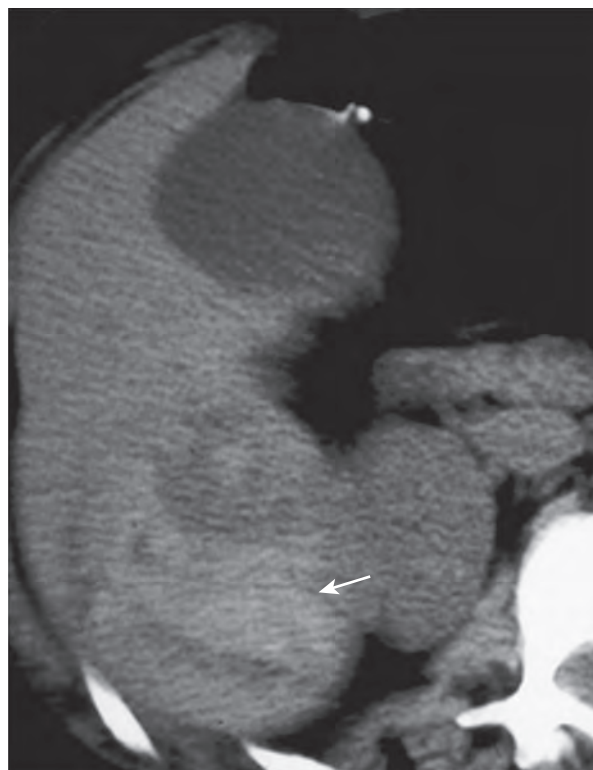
Adenoma: noncontrast CT features. Hyperdense hemorrhage (arrow) is present within the right lobe of the liver.
